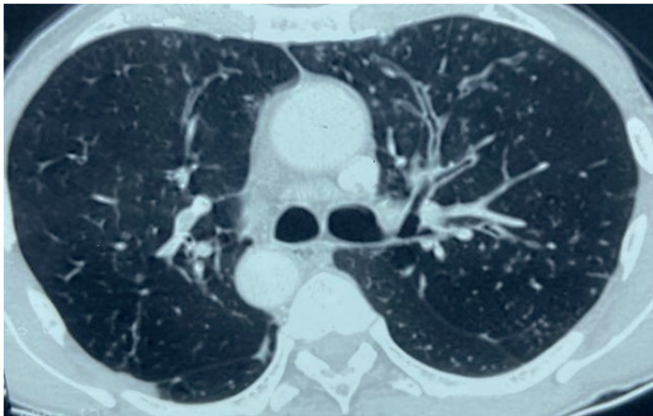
High-resolution computed tomography of chest showing bronchiectasis and emphysema changes with multiple cystic lesions (Case 2).
